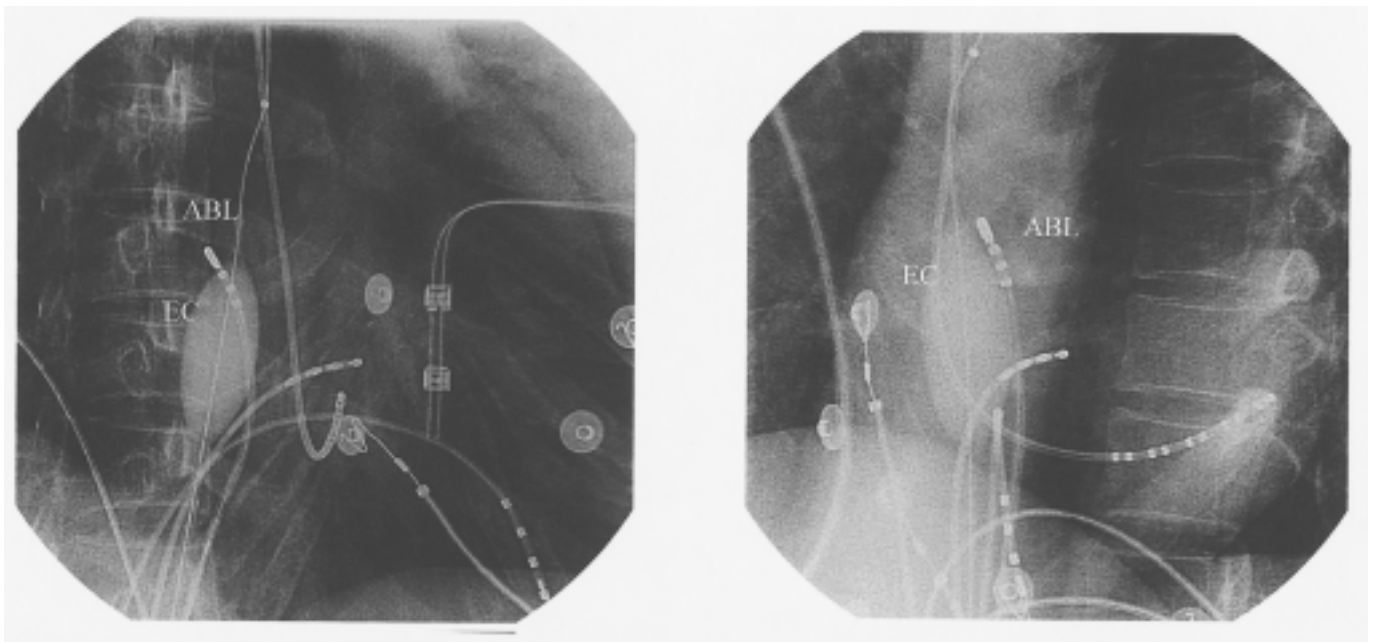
Left Panel. Right Anterior Oblique View. Right Panel. Left Anterior Oblique View. X-rays of patient with focal right atrial tachycardia with Ensite Catheter (EC) in-situ. ABL=Ablation catheter.
